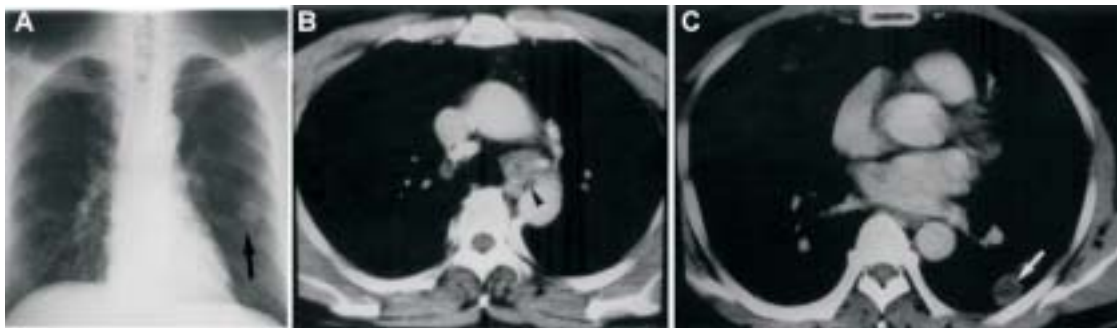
Posteroanterior chest radiography and chest CT. (A) A round mass (2 × 2 cm) was visible in the middle zone of the left lung (black arrow). (B and C) Chest CT showed a mediastinal node (arrowhead) and a relatively well-defined small hypodense round mass at the superior segment of the left lower lobe in the subpleural distribution (white arrow).
